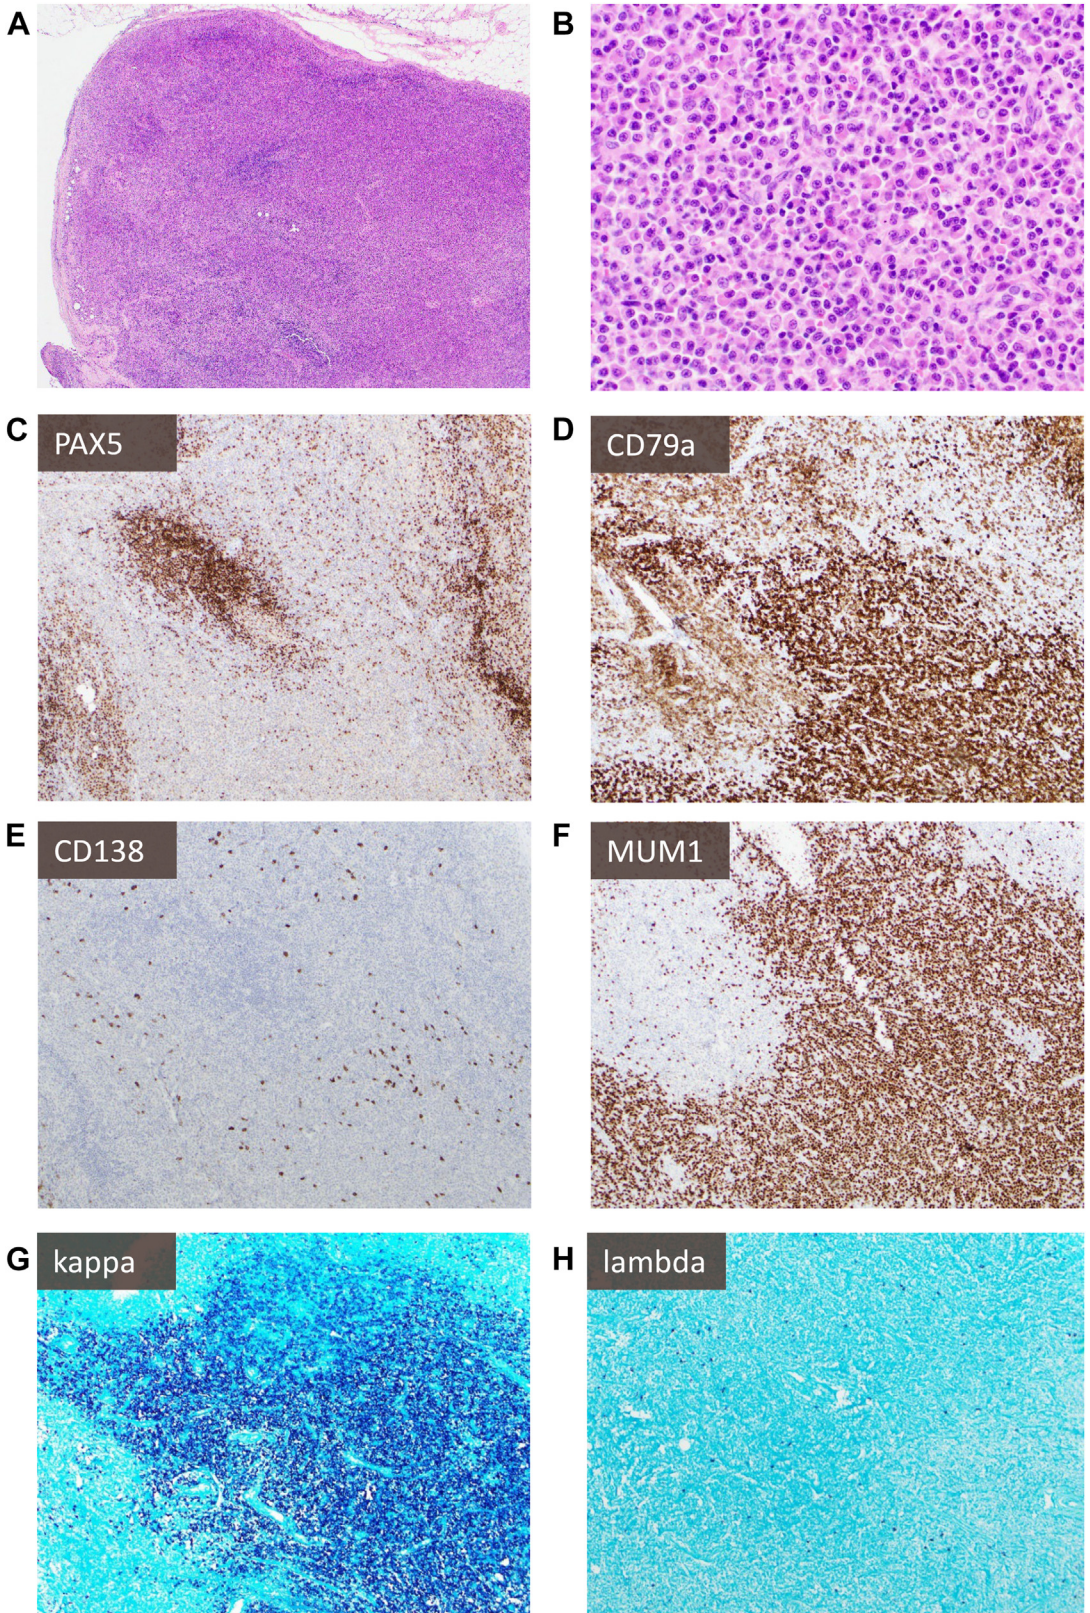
Kappa-predominant plasmacytoid proliferation in a patient with a history of lymphoma: A patient with stage IV diffuse large B-cell lymphoma developed new FDG-avid lymphadenopathy concerning recurrent lymphoma (note: case has previously been published,⁵⁵ new images were taken for this publication with permission).
